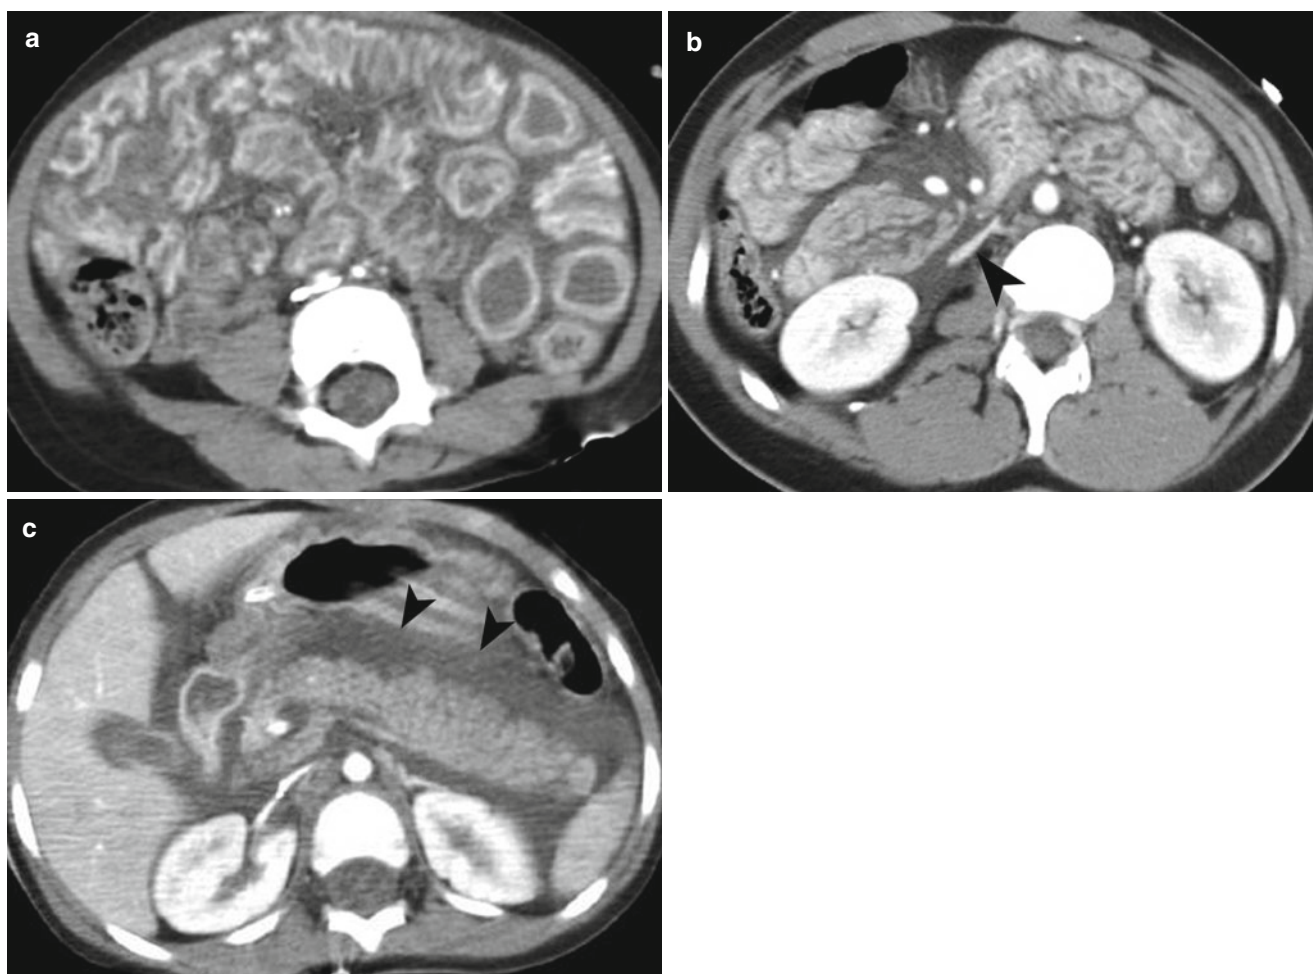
Shock bowel syndrome. (a and b) Contrast-enhanced CT shows hyperenhancing small bowel walls and ascites. The IVC (arrowhead) is flattened secondary to hypovolemia. (c) Contrast-enhanced CT shows peripancreatic fluid (arrowheads) and flattened IVC
